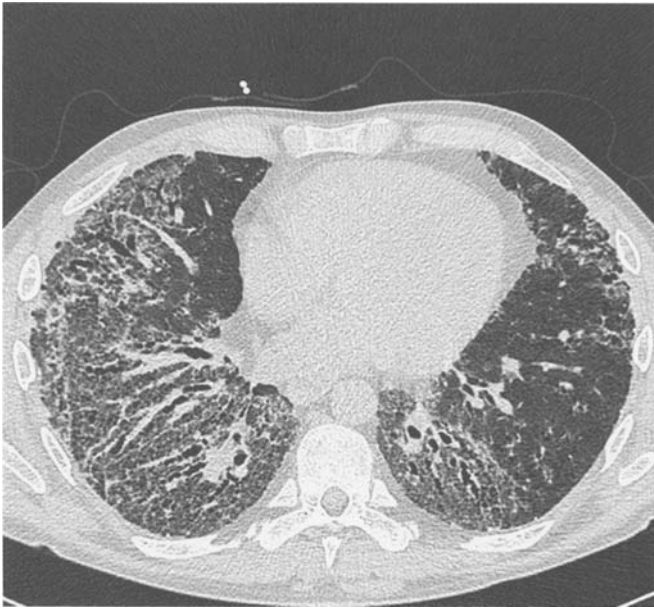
An HRCT of fibrotic nonspecific interstitial pneumonia shows coarse reticular shadowing and traction bronchiectasis, but no honeycombing.
